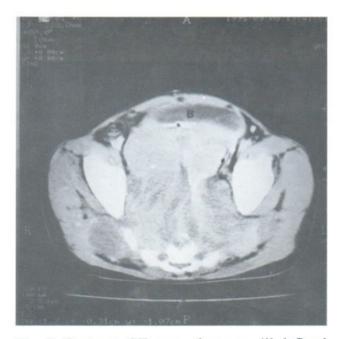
Contrast CT scan shows an ill-defined inhomogeneous soft tissue mass in the pelvic cavity. The mass has extended through the pelvic side walls and destroyed the sacrum. (B= urinary bladder)
